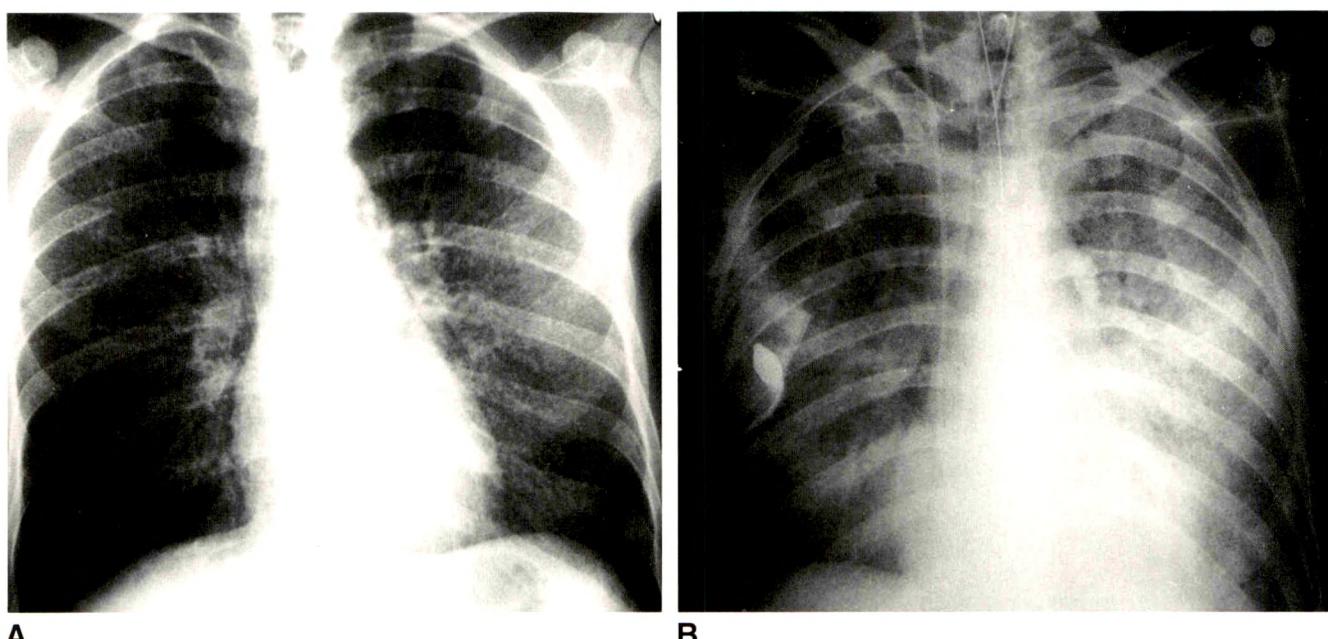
34-year-old man known to have HIV infection had cough and dyspnea, which had gradually worsened over previous 2 months. A, Initial chest radiograph shows diffuse nodular opacities. Disseminated histoplasmosis was diagnosed and antifungal therapy was begun. B, Radiograph obtained 2 days after A shows progression to diffuse air-space opacities.
